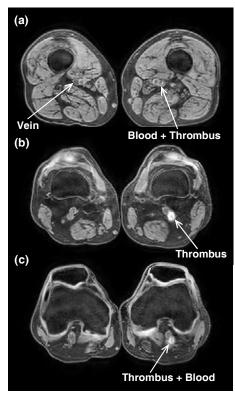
Transverse Slices of T1-weighted 3D dataset taken at different levels through the thrombus.
